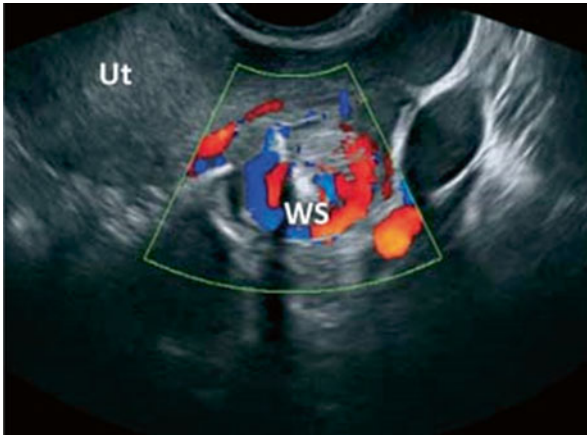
Whirlpool sign with color Doppler. *Ut* uterus, *WS* whirlpool sign (Reprinted from Valsky et al. [8], with permission of John Wiley & Sons, Inc.)
